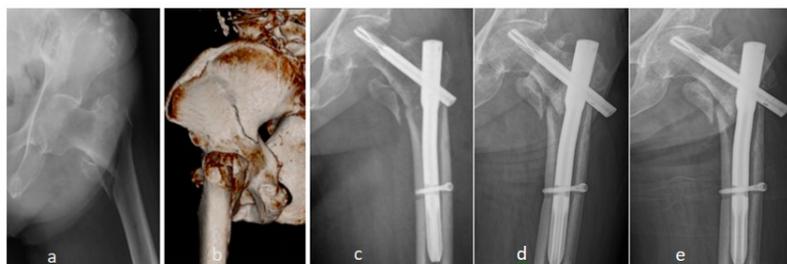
An 81-year-old female diagnosed with an intertrochanteric fracture accompanied by a coronal fracture block. (a–b) Preoperative imaging showing intertrochanteric fracture with coronal fracture. (c) X-ray at 1 day postoperatively; (d–e) X-rays at 6 and 12 months postoperatively, showing neck–shaft angle shortening and nail back-out.
